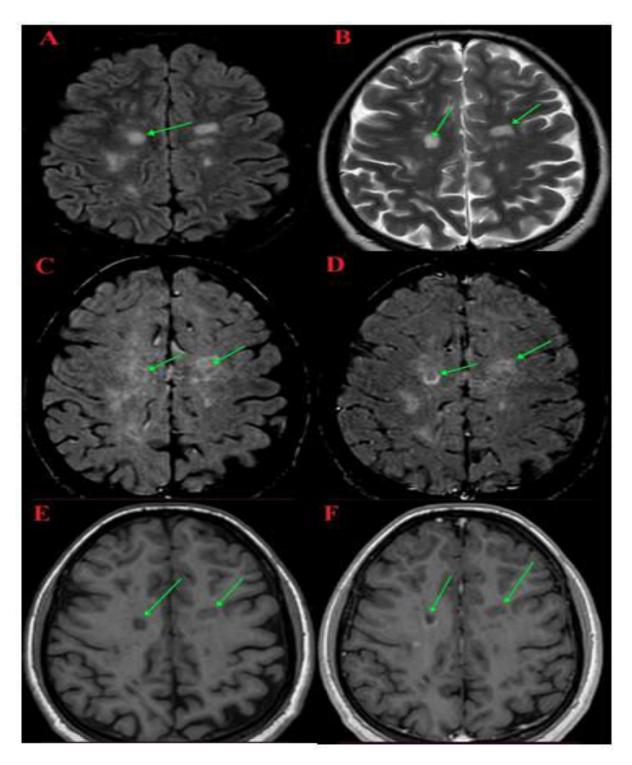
A 22-year-old female patient, presented with Hemiparesis, lumber weakness and numbness of two weeks duration. (The initial MRI) A & B): axial FLAIR and Axial T2WI: Show bilateral subcortical white matter hyperintense plaques, C): Axial pre contrast Susceptibility Weighted Images (SWI): Shows white matter hyperintense plaques with central vein sign supporting diagnosis of MS, D): Axial post contrast Susceptibility Weighted Images (SWI): Shows multiple white matter hyperintense plaques, the largest on the right side show ring shape enhancement and two central vein sign supporting diagnosis of MS. that is characterized more obvious by the GD-SWI sequence more than pre contrast SWI, E & F): Axial T1WI (pre and post contrast study): The both shows white matter hypointense plaques that show ring enhancement in post contrast T1WI. The clinical and the radiological findings are consistent with active demyelinating disease (MS).
